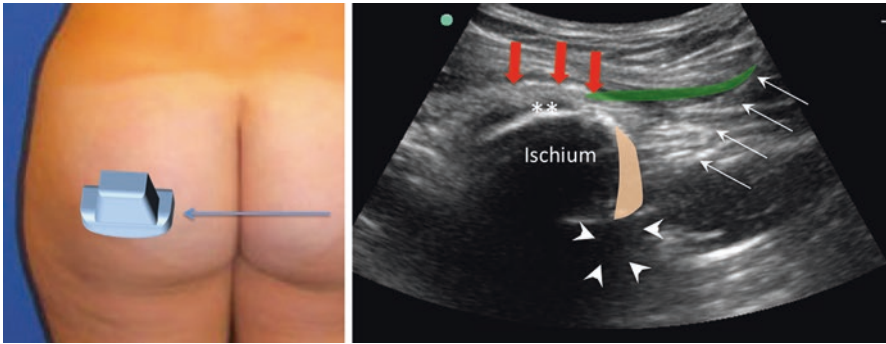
Figure showing the ultrasound probe and needle position on the left side and the corresponding sonography on the right side. Obturator internus muscle, solid beige color; obturator internus tendon, bold red arrows; , obturator internus bursa; sacrotuberous ligament, green color; line arrows, needle; arrowheads, injectate. (Reprinted with permission from Philip Peng Educational Series)
